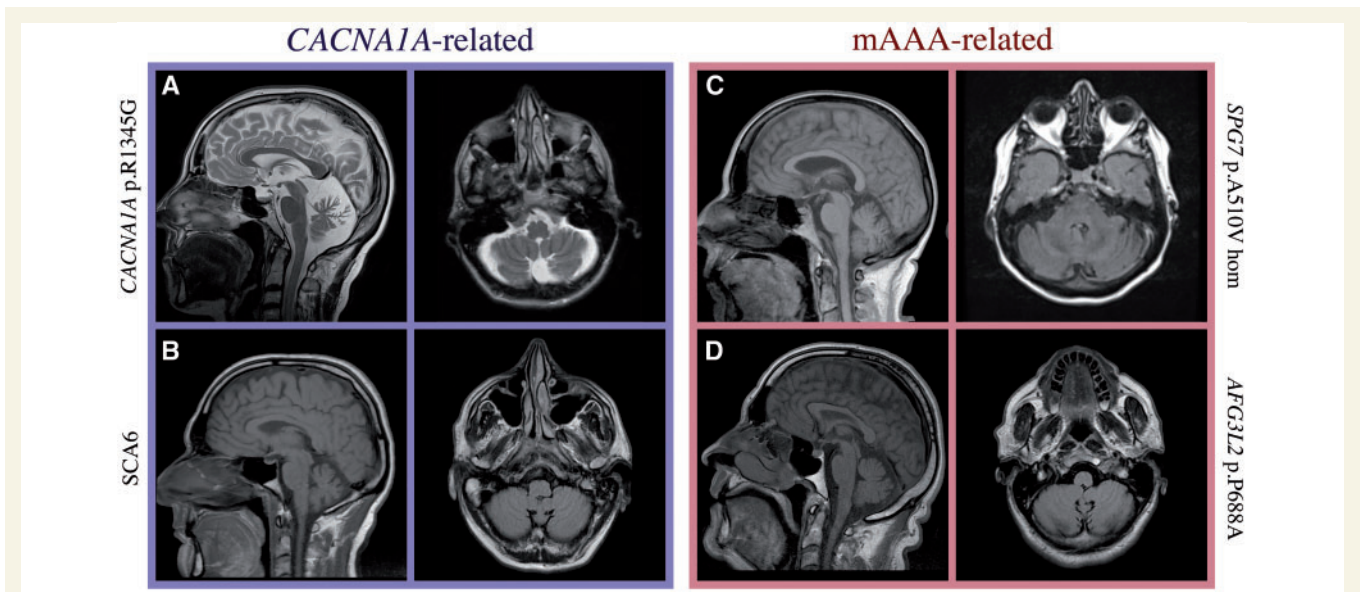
Brain MRI of patients carrying mutations in *CACNA1A* (point mutations and expansion), *SPG7* and *AFG3L2*, with similar severity indexes. (A) T₂-weighted sagittal and axial brain MRI showing marked cerebellar atrophy of Patient AAD-870, *CACNA1A* mutation p.R1345Q; age at onset: 28; age at examination: 52; severity index 0.13. (B) T₁-weighted sagittal and T₂ FLAIR axial brain MRI showing cerebellar and brainstem atrophy of Patient AAD-980, SCA6 [(CAG)_n = 27]; age at onset: 45; age at examination: 47; severity index 0.5. (C) T₁-weighted sagittal and axial brain MRI showing mild cerebellar atrophy of Patient AAD-1033, *SPG7* homozygous mutation p.A510V; age at onset: 57; age at examination: 70; severity index 0.15. (D) T₁-weighted sagittal and axial brain MRI showing slight vermian atrophy of Patient AAD-1009; *AFG3L2* mutation p.P688A; age at onset: 47; age at examination: 57; severity index 0.1. Brainstem atrophy (arrow) is only noticed in the SCA6 patient, which is in line with the observed phenotypic differences. Cerebellar atrophy is more prominent in *CACNA1A*-related ataxias, and in particular in point mutation cases, than in mAAA-linked cases.
